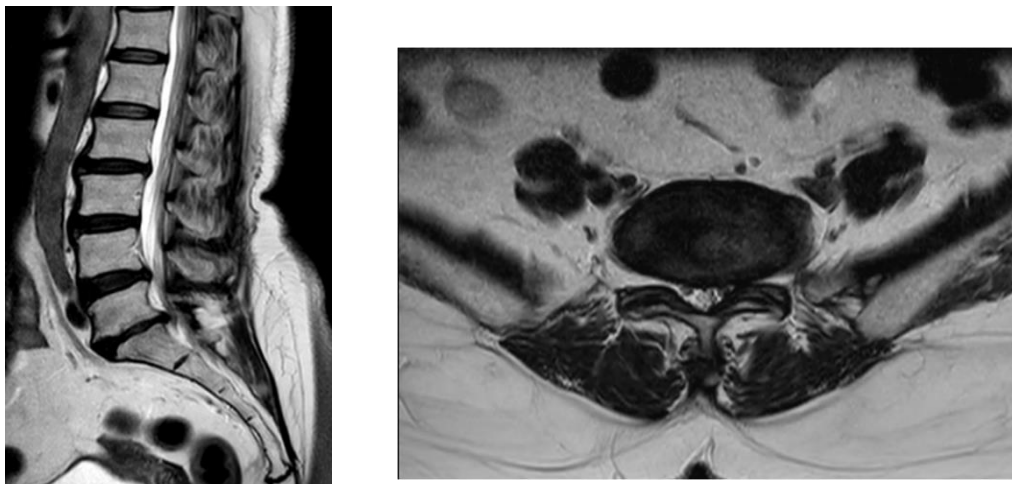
MRI films showing left posterolateral disc herniation at L5-S1 level
